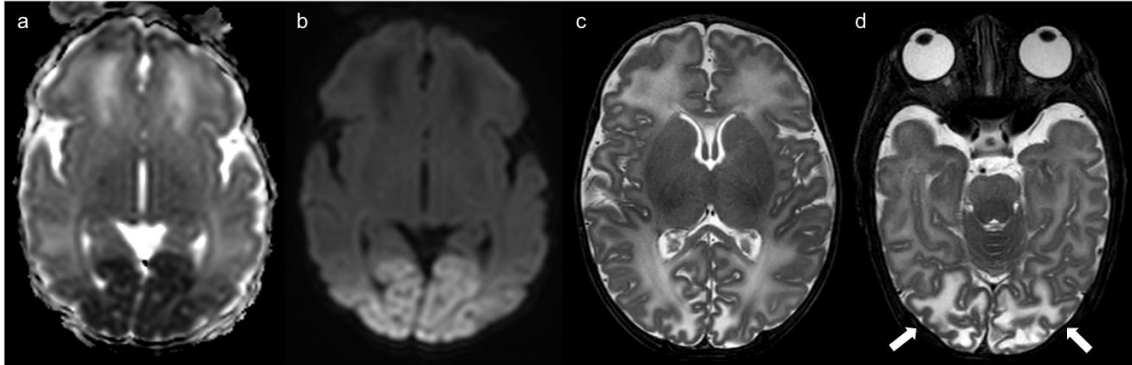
Hypoglycemia occipital cortex damage in a newborn. At birth damage manifests as restriction in (a) ADC maps and (b) DWI b1000 imaging. At 1 month of age is visible in T2-weighted imaging (c-d).
